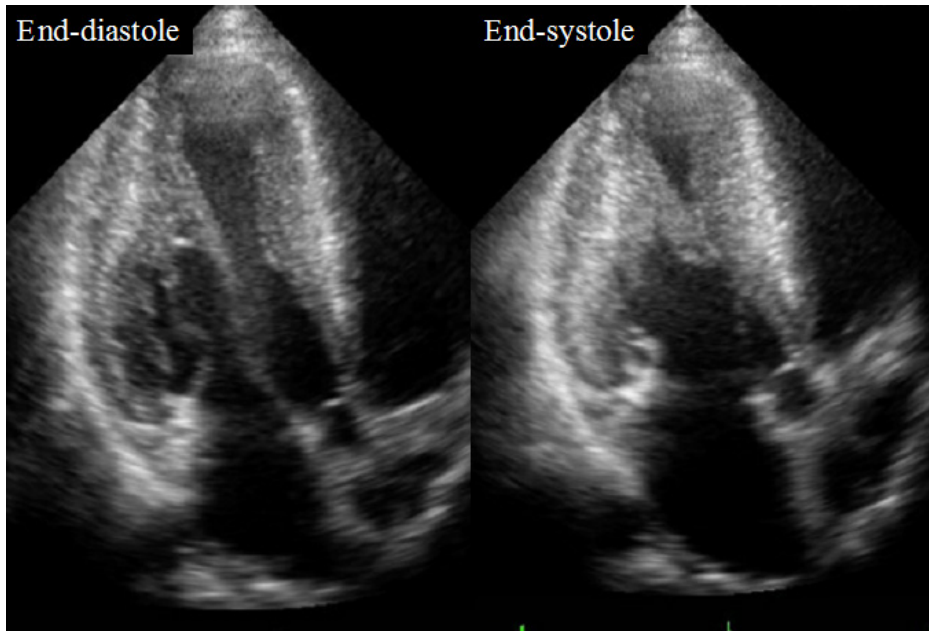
Echocardiography of a representative case
